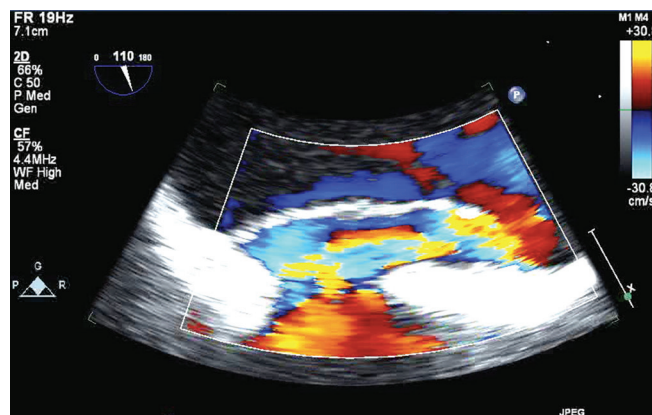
Echocardiographic evaluation of patent foramen ovale after cardiopulmonary bypass. Indicated in bicaval view of color flow Doppler transesophageal echocardiography
